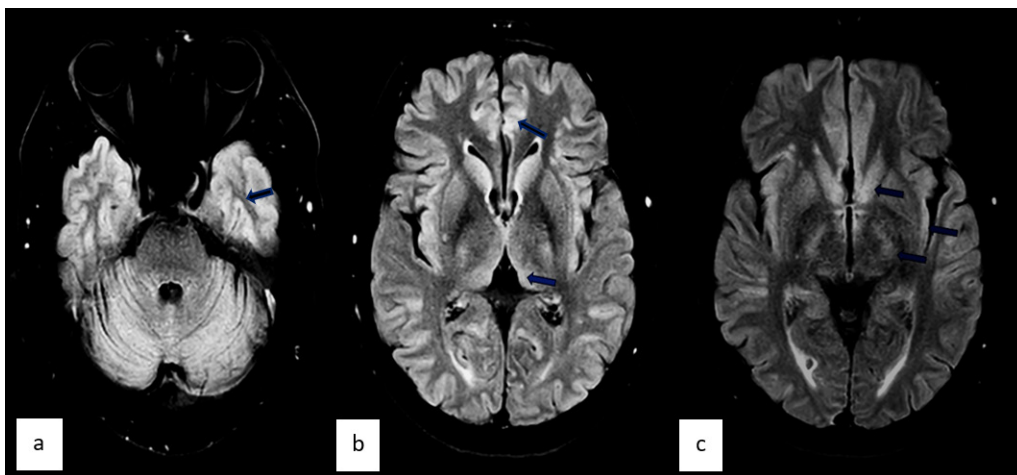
Axial FLAIR (a, b, and c) shows bilateral symmetrical hyperintensities at inferior temporal lobes, medial thalamus, cingulate gyri, caudate head, posterior limb of internal capsules and insula
